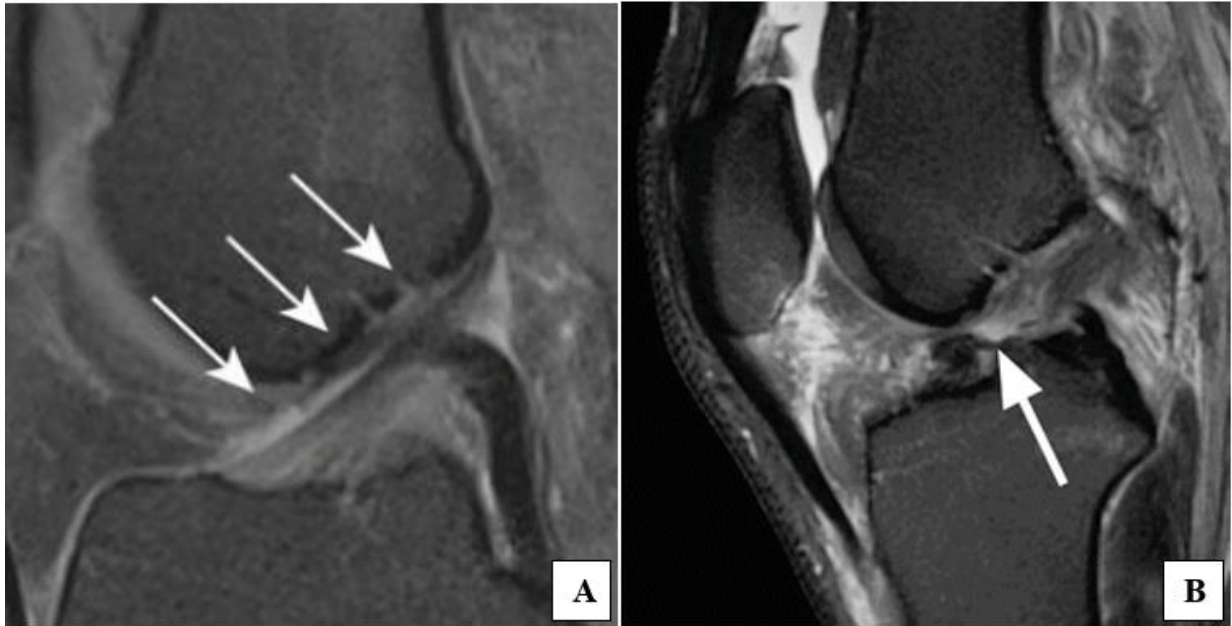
(A) Sagittal proton density weighted fat saturated (PDFS) image showing subtle inter-substance hyperintensities (arrows) *S/o Sprain*. (B) Sagittal T2-weighted fat-suppressed image shows complete discontinuity of the ligament adjacent to the tibial insertion (*arrow*) suggesting complete tear.
